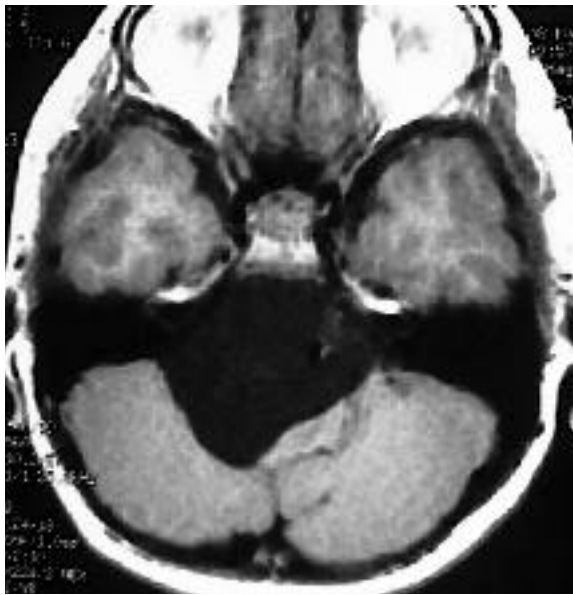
T1-weighted MR axial image. Hypointense large midline retroclival mass more to the right causing shift of brainstem to the left and mass effect on the right cerebellum.
